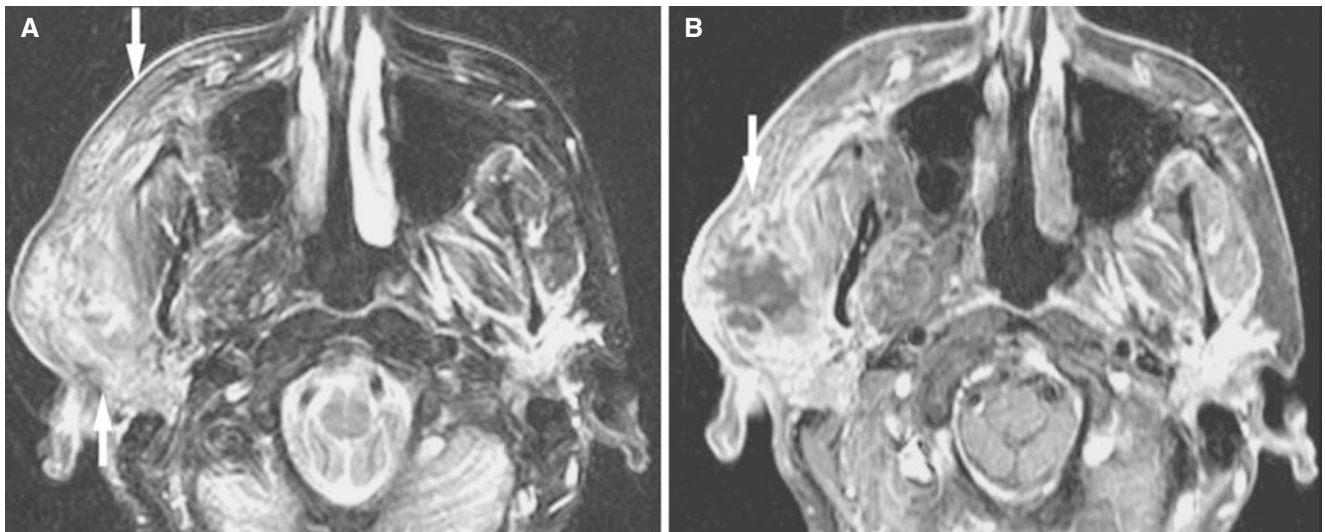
Abscess and cellulitis in parotid region; 52-year-old female with right parotid swelling and pain and clinical suspicion of abscess. (A) Axial T2-weighted fat-suppressed MRI shows diffuse high signal in the right lateral half of the face consistent with subcutaneous edema and cellulitis (*arrows*). (B) Axial T1-weighted fat-suppressed post-Gd
